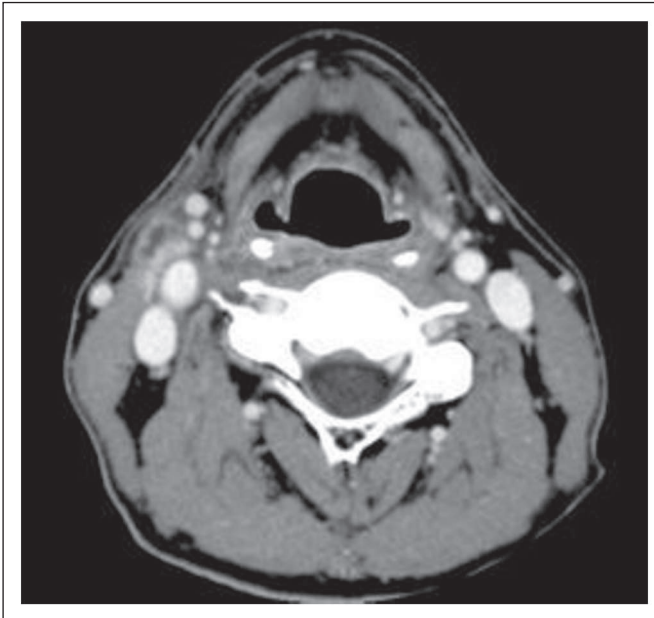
This 44-year-old patient received radiotherapy (76.2 Gy at 1.2 Gy/fraction bid) for T2N2b base of tongue cancer. Postradiotherapy computed tomography demonstrated a 1.4-cm lymph node with definite (grade 4) focal lucency and focal enhancement in the right neck at level II. Neck dissection was positive, and the patient was controlled with 7 years of follow-up.
